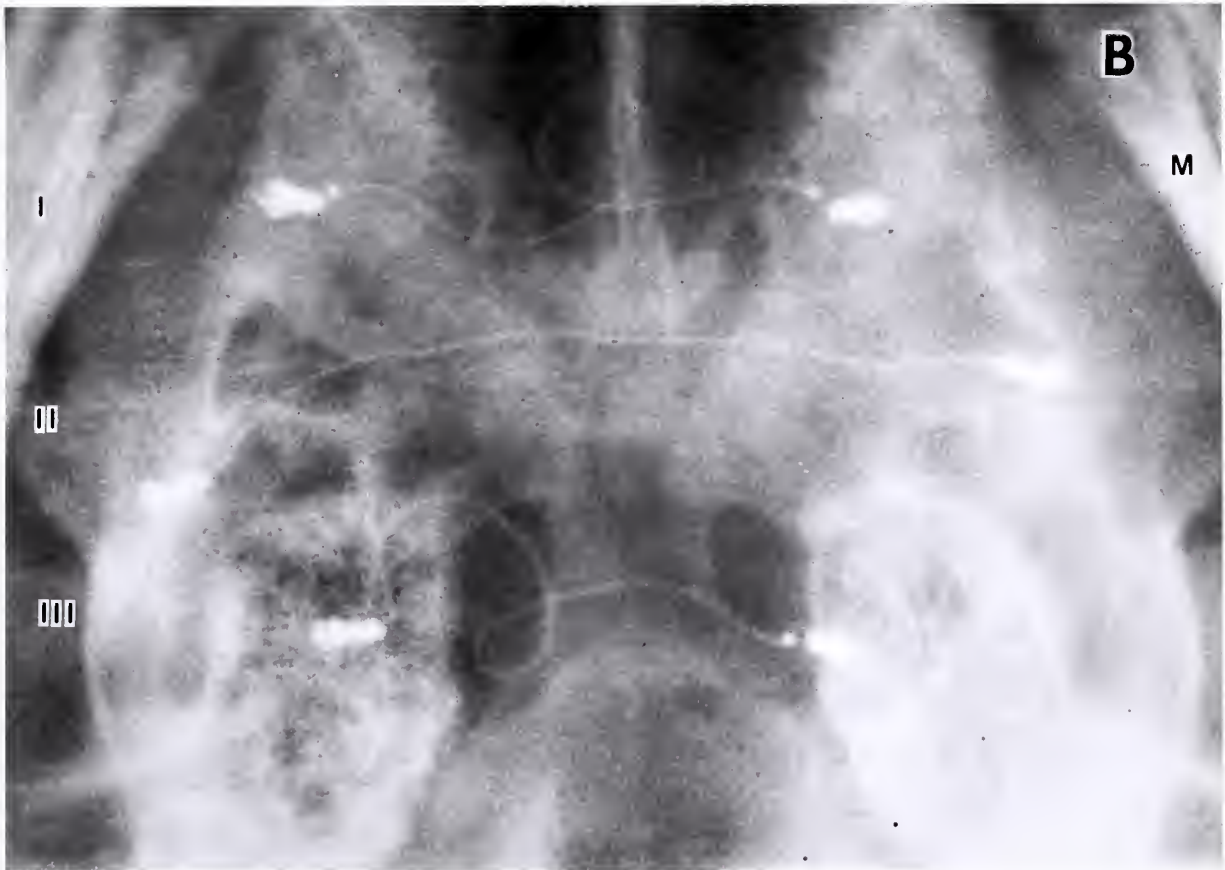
AP plain film obtained at 12 weeks. The electrode wires and screws are shown at the same scale as in figure 4a (x 2). Skull growth can be noted by the increased distance between the rami of the mandible (M) over time. Electrode expansion is evident by the tightened loops in devices I and III and by the flattened wire in device II.
